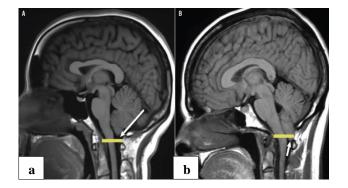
MRI brain of a person (a) without CM, and (b) with CM I (the cerebellar tonsils (white arrow) descend more than 5 mm below the level of the foramen magnum (yellow line)).
